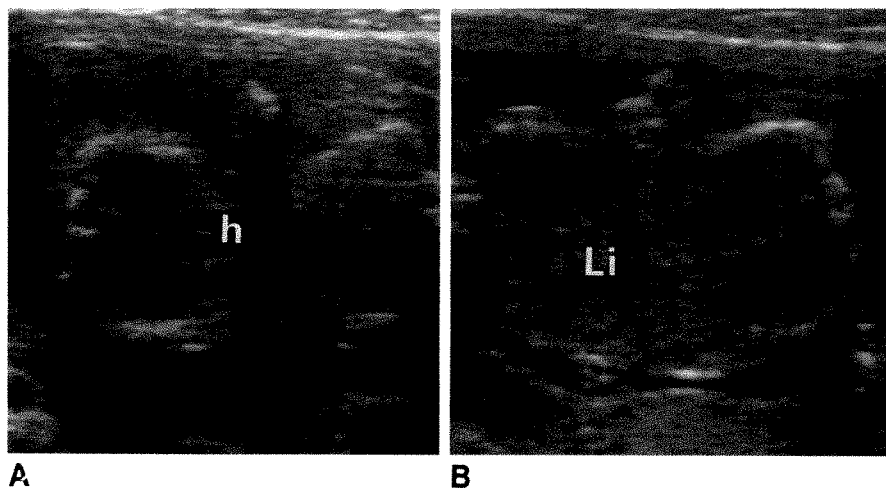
A and B, Thoracoomphalopagus twins diagnosed with sonography at 11 menstrual weeks. c = cephalic pole.
